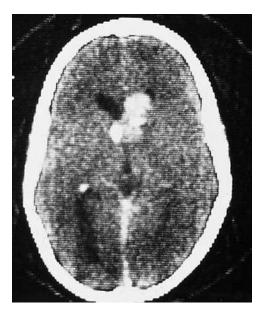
Tuberous sclerosis. CT scan demonstrates a large subependymal astrocytoma, which intermittently obstructed the ventricular system, producing episodic symptoms of increased intracranial pressure. (*Courtesy Division of Neuroradiology, University Health Center of Pittsburgh, Pittsburgh, Pa.*)
